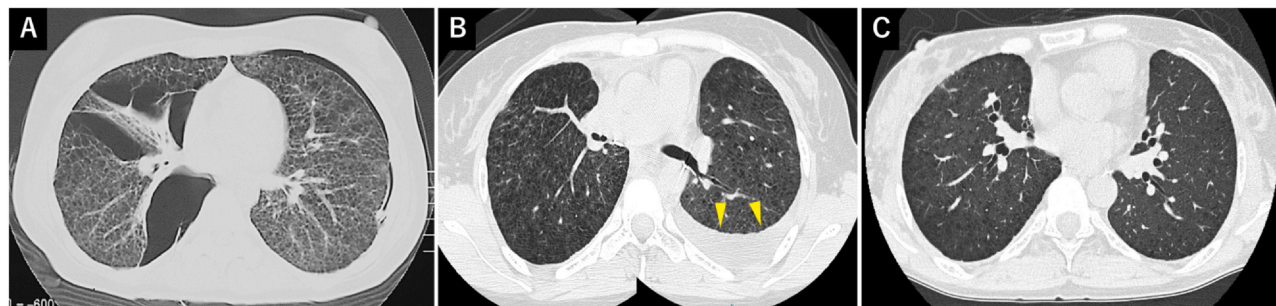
Chest computed tomographic (CT) image of the recipient. (A) Lymphangioleiomyomatosis before bilateral living-donor lobar lung transplantation (LDLLT). (B) CT image showing newly emerging cystic changes in both the transplanted lobar lungs along with left pleural effusion (arrow heads) 5 years after the LDLLT. (C) The recipient had survived without the development of chronic lung allograft dysfunction for 23 years (at the time of writing) after the LDLLT.
